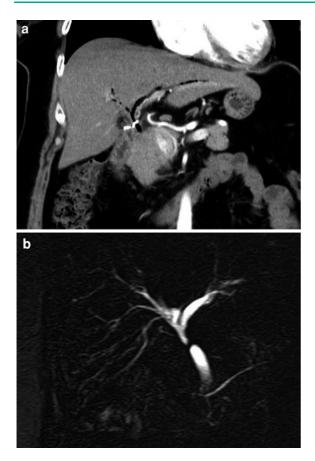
a contrast-enhanced CT scan (coronal plane): pneumobilia post ERCP; note the metallic clip postcholecystectomy just below the primary biliary confluence, responsible for the stenosis. b MR cholangiography: Complete stenosis of the common bile duct below the primary biliary confluence which occured lately after a postcholecystectomy bile duct leak
